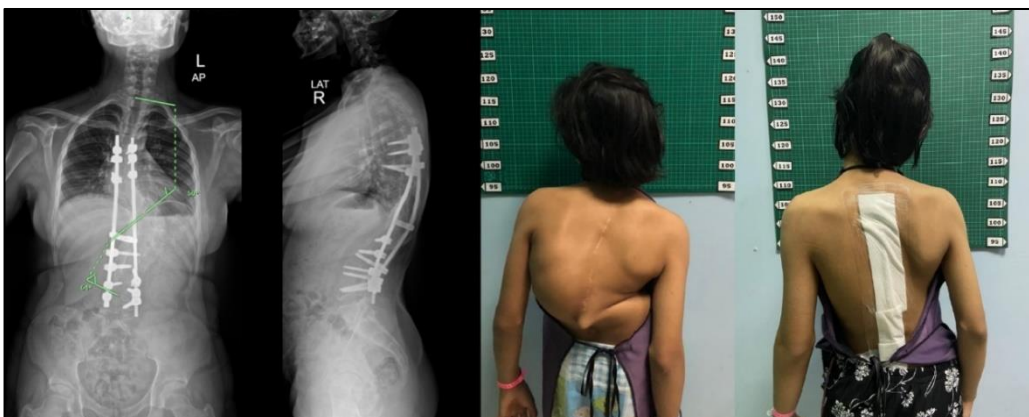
Post-operative radiographs with clinical pictures pre-and post-operatively after growing rod removal and PSIF
